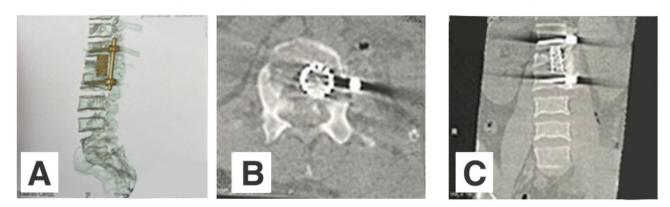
Post-operative CT Lumbosacral spine showing the construct and instrumentation; A: 3D reconstruction image, B: axial and (C): Coronal image.
